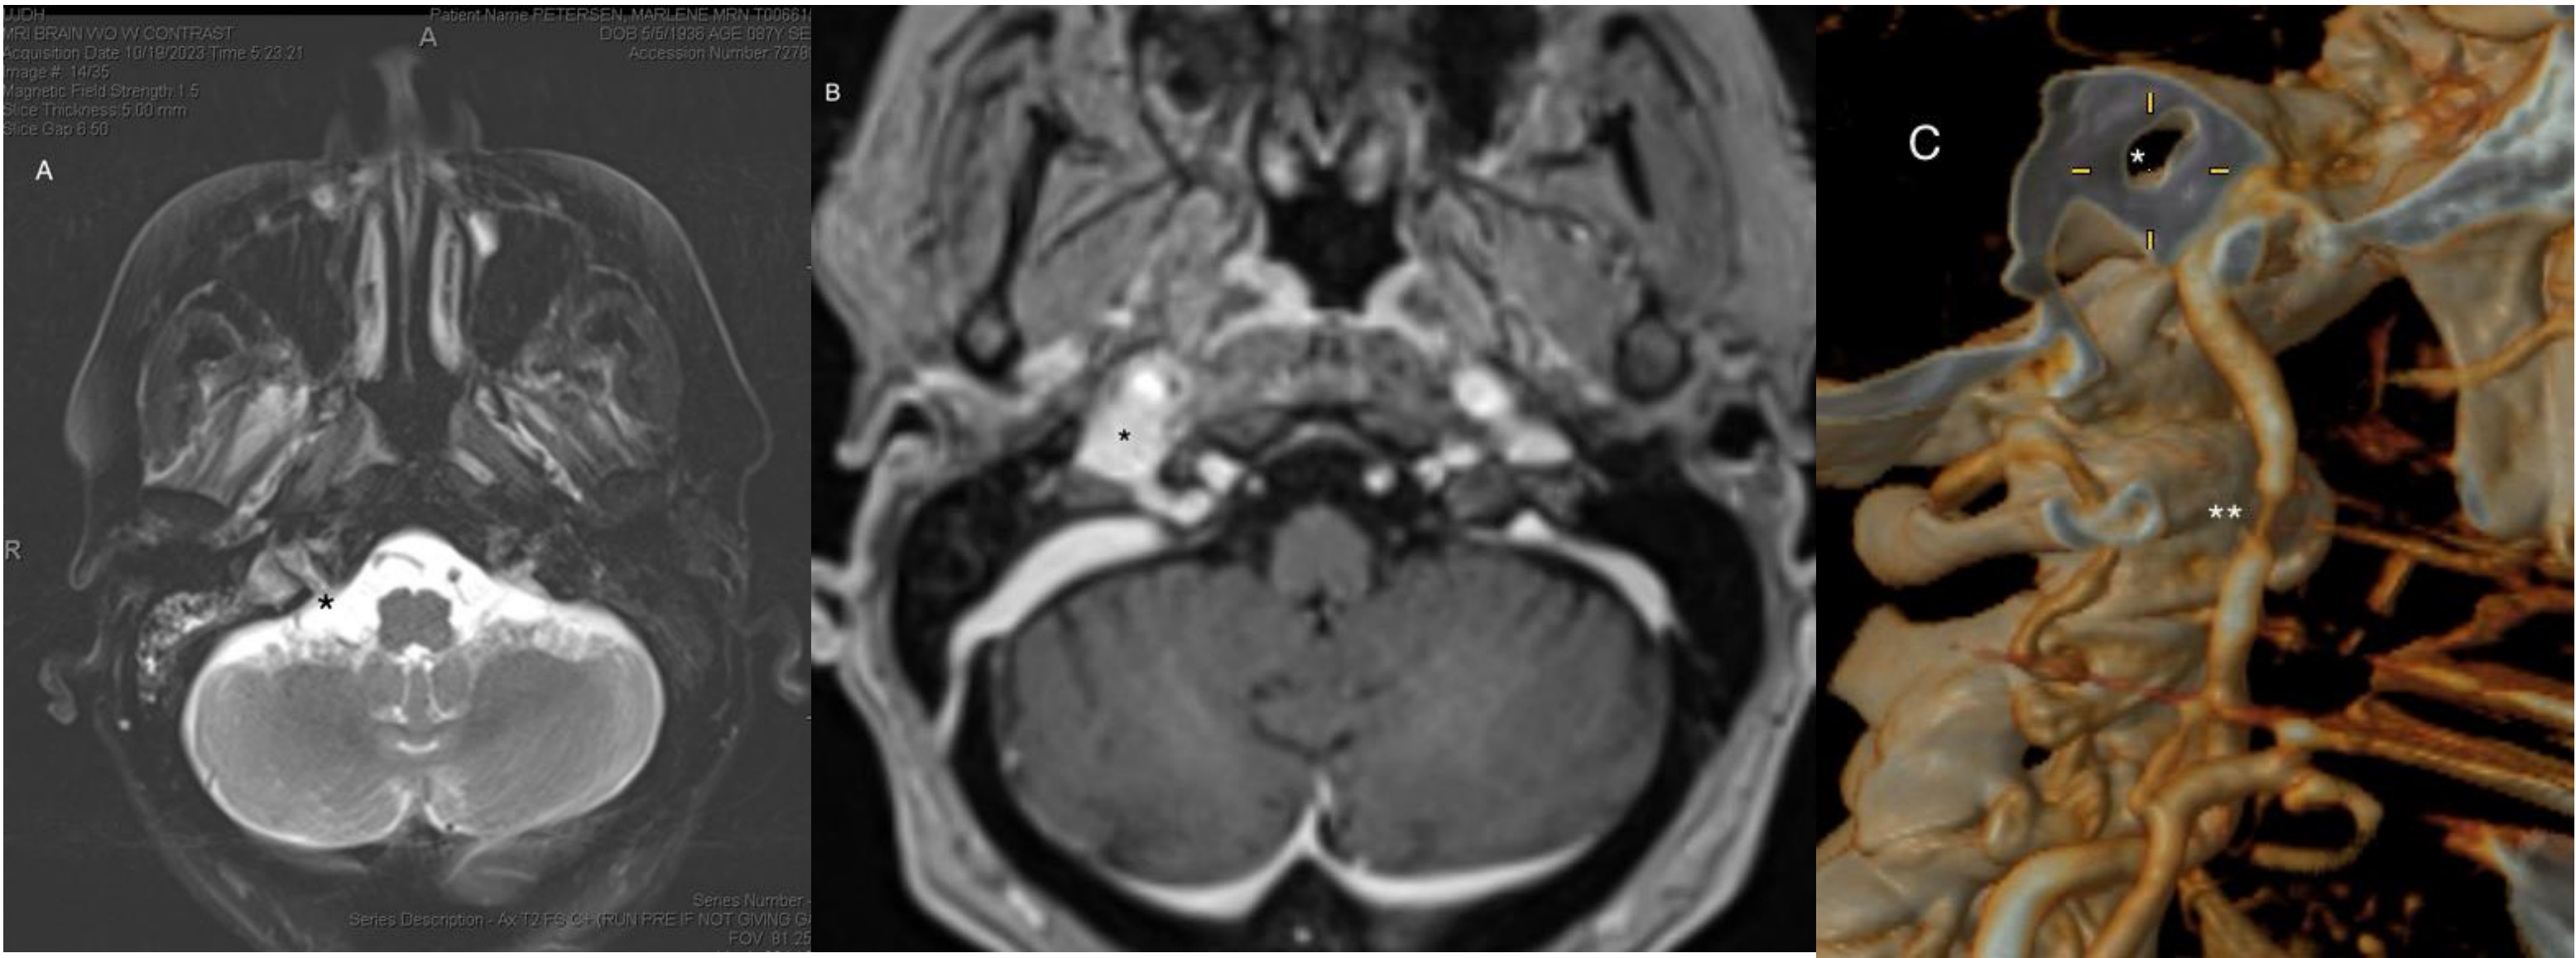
Figure 2A, above, depicts MRI Brain with edema along the expected course of cranial nerve XII through the hypoglossal canal (*, above). Figure 2B, above, depicts area of abnormal enhancement just posterior to the carotid sheath and abutting the hypoglossal canal (*, above). Figure 2C, above, 3D reconstruction showing narrowing of hypoglossal canal (*, above) and of the carotid artery (, above).
